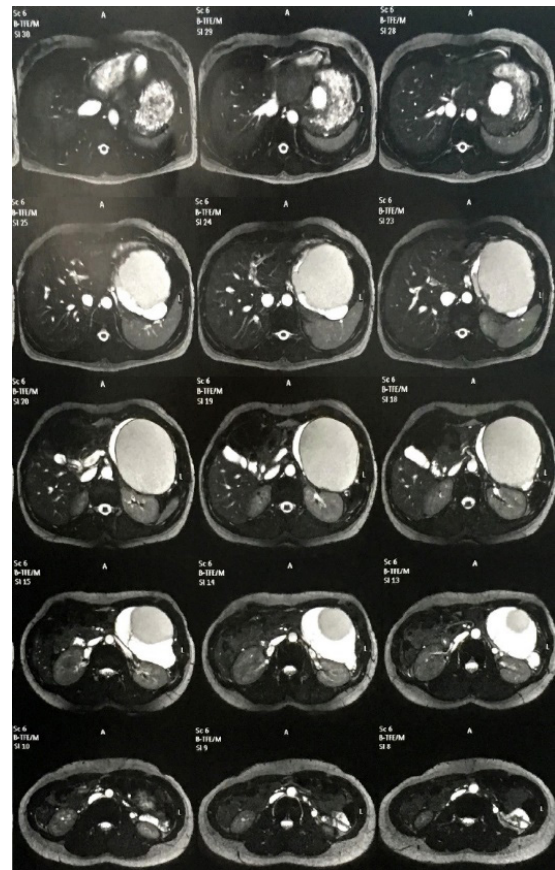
Axial computed tomography sections of the abdomen suggestive of a cystic neoplastic lesion in close relationship with the body/tail of the pancreas, measuring approximately 13.9 x 11.9 x 10.3 cm (author's personal file, 2019).
